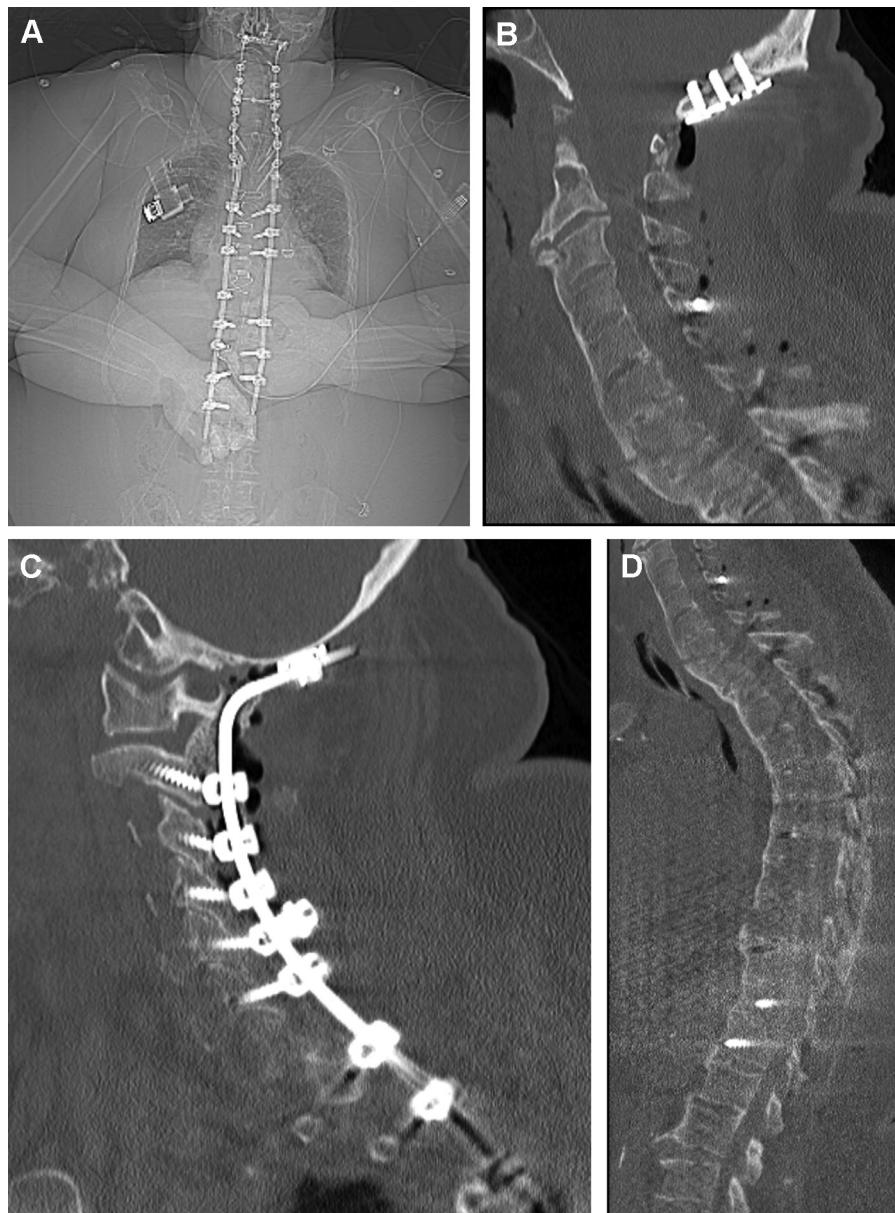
(A) Postoperative computed tomography (CT) scout image; (B and C) postoperative CT of the occipitocervical fusion; and (D) postoperative CT of the percutaneous thoracolumbar fixation mated to the occipitocervical instrumentation.
